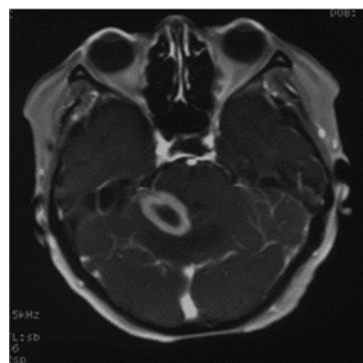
Abnormal circular hyperintense tumor in MRI.
